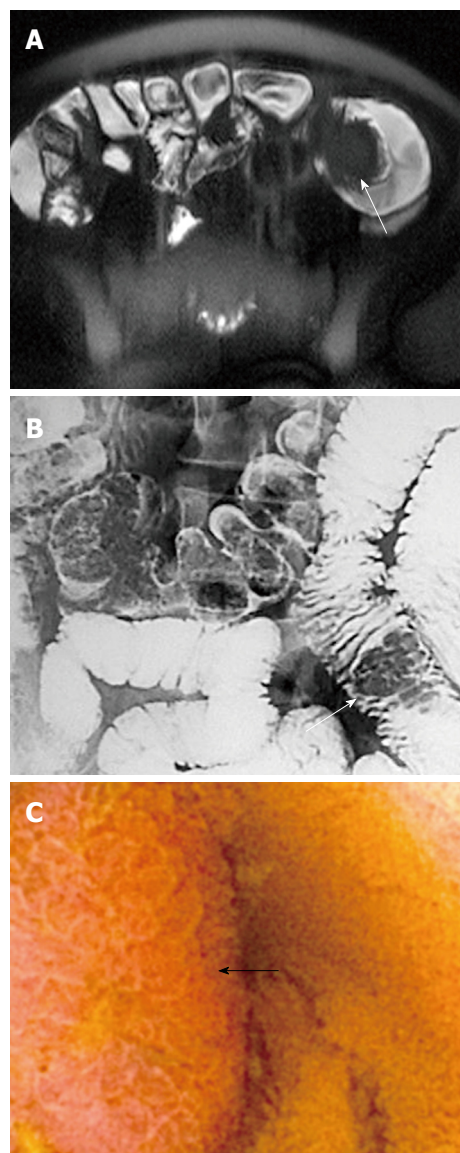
Hamartoma of the jejunum (arrow). A: Magnetic resonance imaging; B: Enteroclysis; C: Capsule endoscopy.
